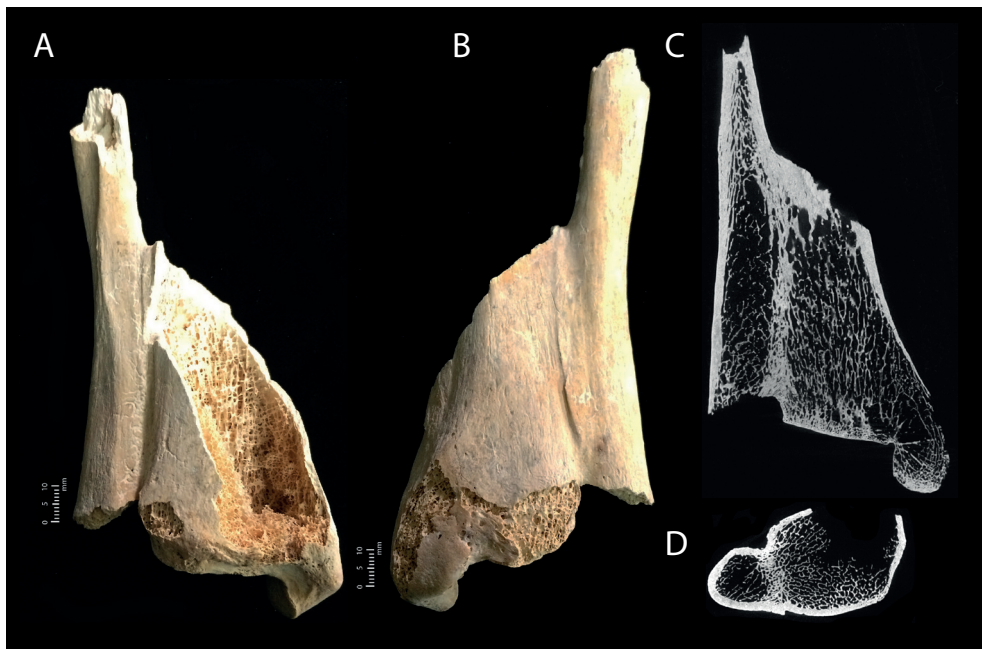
Photographic and radiological images pertaining to fragmentary adult right tibia and fibula (FB0003) from Context (783) of the Circle sample, detailing complete fusion of the distal diaphysis and metaphyses at the interosseous border, including: a) anterior view; b) posterior view; c) coronal cross-section from CT data detailing the complete extent of fusion; d) transverse cross-section at the fusion site detailing the commonality of trabeculae. Scale bar: 1 cm (photographs only). (Photos Ronika K. Power; radiological images captured by L. Buck, Cambridge Biotomography Centre; processed by J. Magnussen & M. Pardey, Macquarie Medical Imaging).
